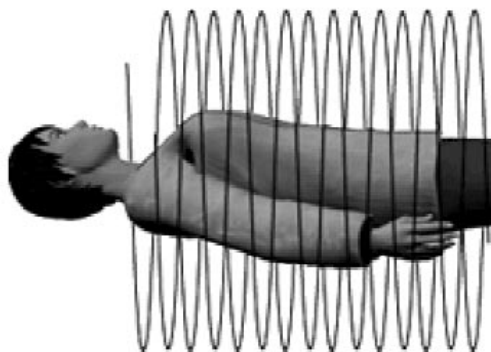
CT Scanner rotates helically around a patient
